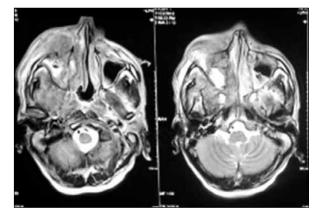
MRI scan report showing right maxillary sinus problem: The ill-defined disease is involving the right pre-septal space, extending posteriorly to the right maxillary ethmoid, sinus and orbital apex. The disease is infiltrative in nature with ill-defined borders.
